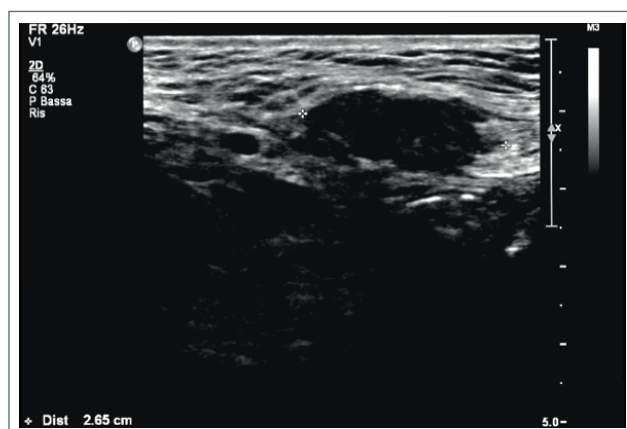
Abdominal ultrasound (November 2015): multiple subcutaneous solid hypoechoic nodules with a poorly defined and irregular borders and irregular shape were found out in abdominal wall (Linear probe – Philips IU22).
